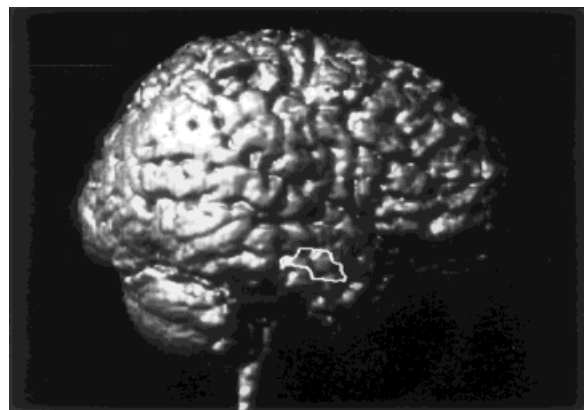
A 3-D surface rendered display of the segmented MRI scan of an epilepsy patient. The border of the PET-defined defect is superimposed on the cortical surface for an improved assessment of the focus location.
